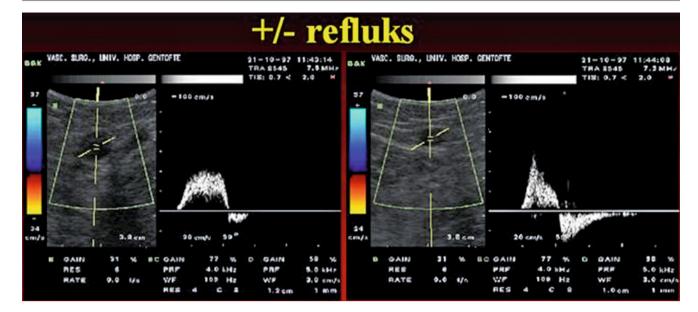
Doppler spectrum from vein with competent valves and Doppler spectrum from vein with incompetent valves
